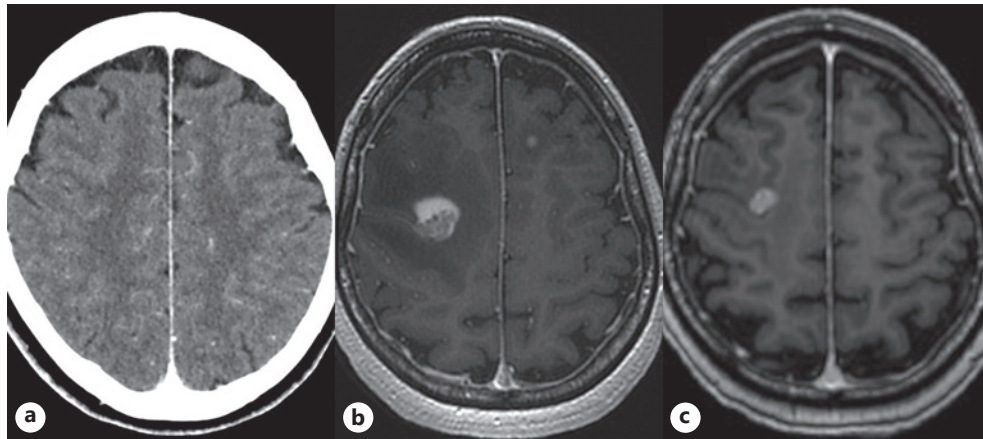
a Enhanced computed tomography images obtained 26 days before the emergency hospitalization, from which brain metastases were not detected. b Enhanced magnetic resonance images on the emergency hospitalization showing a “disease flare” of brain metastases with brain edema. c Image of the same lesions obtained 14 days after entrectinib initiation, which regressed remarkably.
